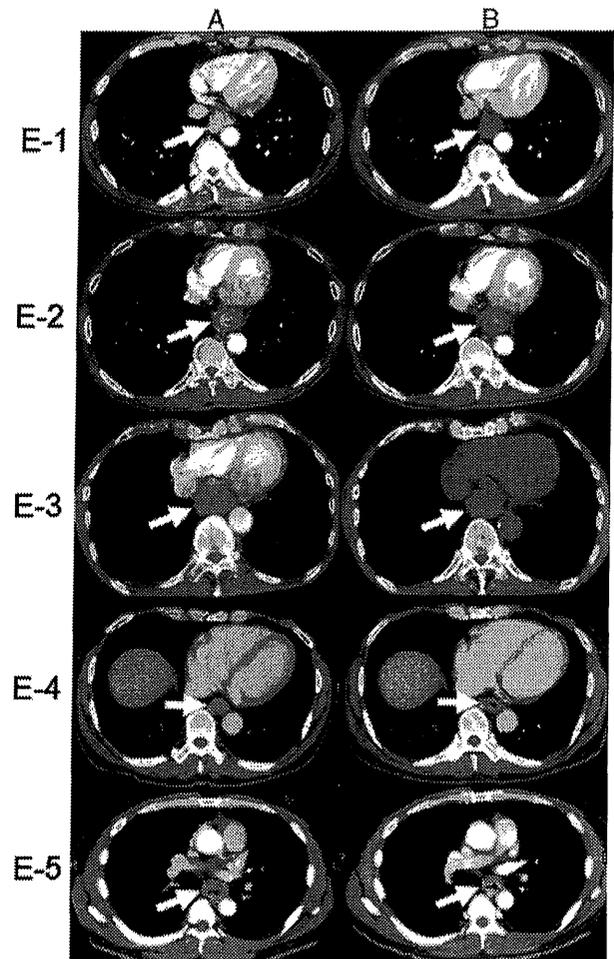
Computed tomography (CT) images of primary esophageal tumors obtained before and after the intratumoral dendritic cell (DC) administration. The primary esophageal tumor (arrow) was located in the lower intrathoracic esophagus region in patients E-1, E-2, E-3, and E-5 and in the middle region of the esophagus in patient E-4. CT images taken after the DC administration and after 2 cycles of chemotherapy (B) showed a marginal decrease in tumor status in E-2, E-3, E-4, and E-5 and a marginal increase in tumor status in E-1 compared with the images taken before the DC administration (A) (Supplementary Table, <http://links.lww.com/JIT/A247>).
